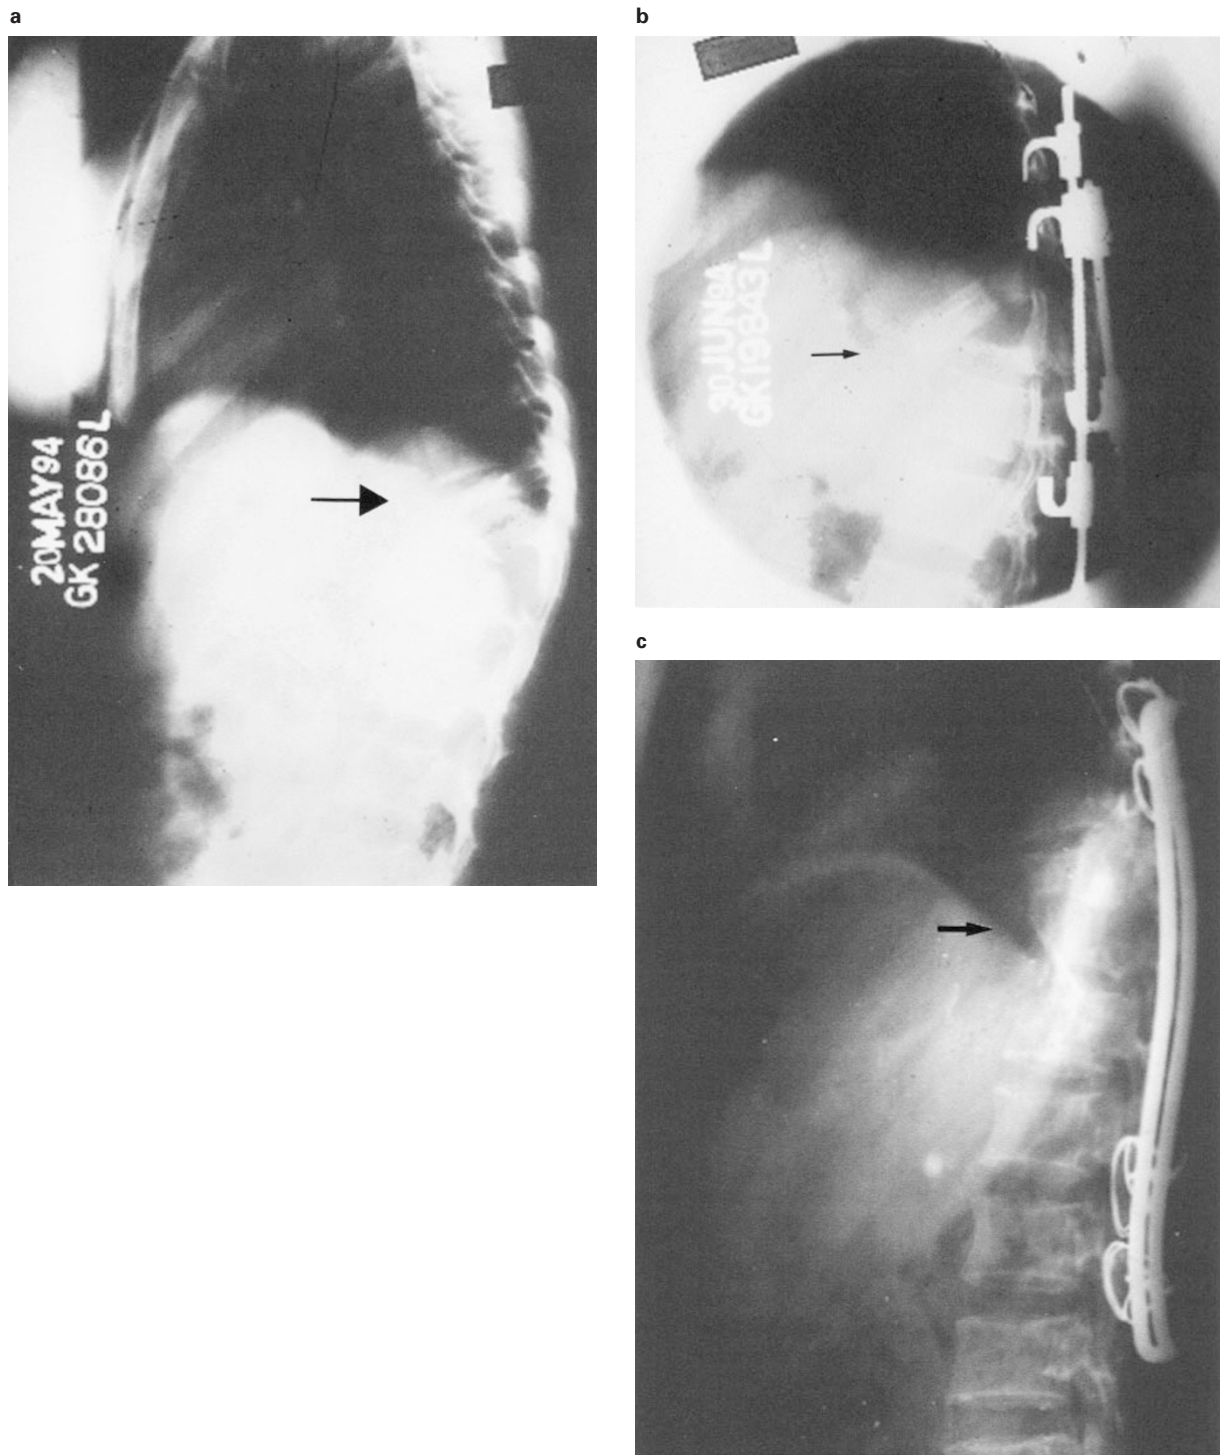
(a) Preoperative X-ray showing D10-11 kyphosis without neurological deficit. (b) Postoperative X-ray showing graft dislodgement and implant failure after use of Harrington compression system. (c) Follow up X-ray showing graft consolidation after revision surgery (Graft repositioning and Hartshill rectangle)
